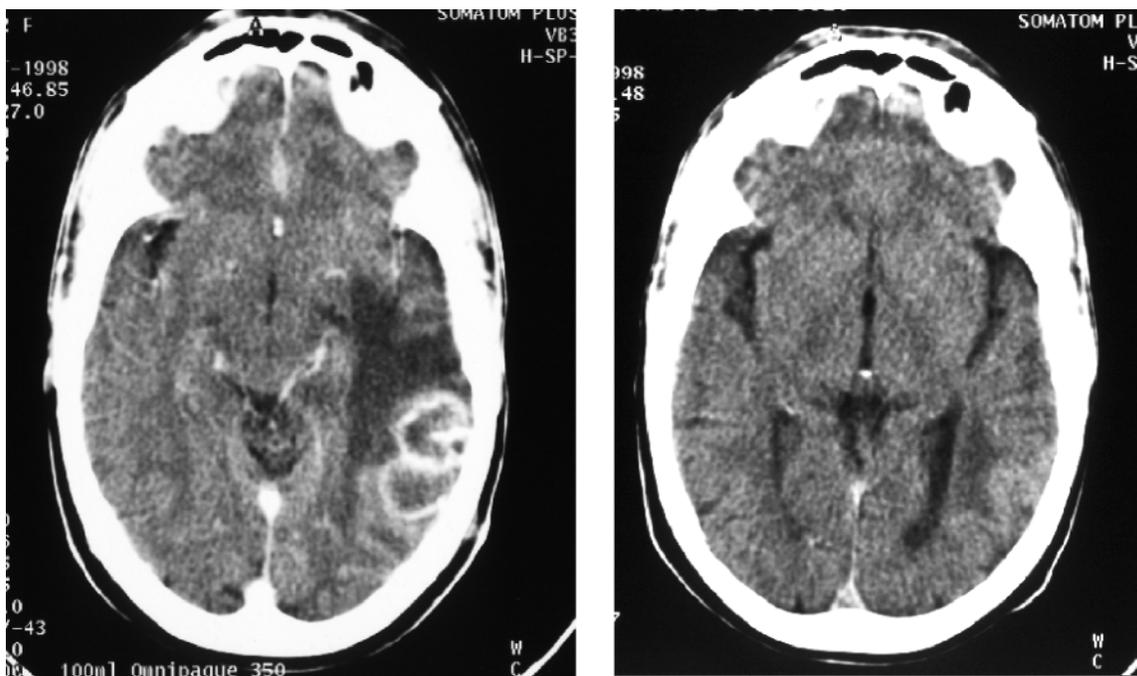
CT scans of a patient with presumed TB at presentation (left) and on anti-TB treatment after 6 weeks (right).
